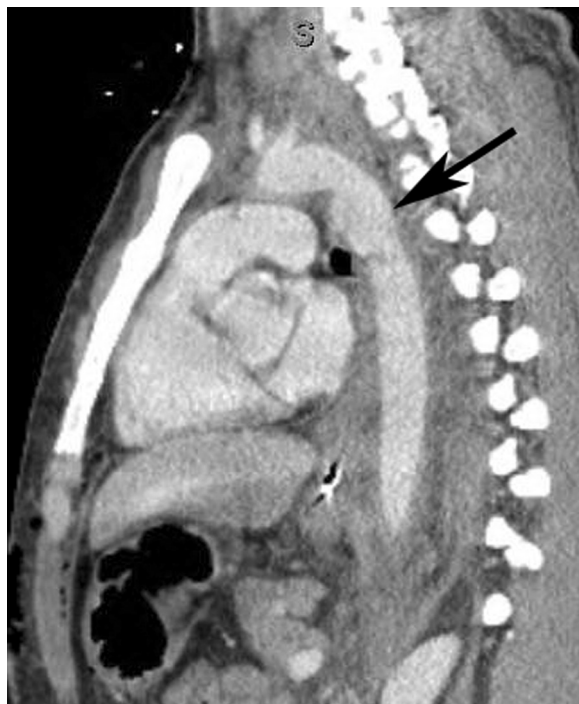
■ Sagittal computed tomography (CT) reconstruction. Acute aortic transection near the level of the ligamentum arteriosum (black arrow).
